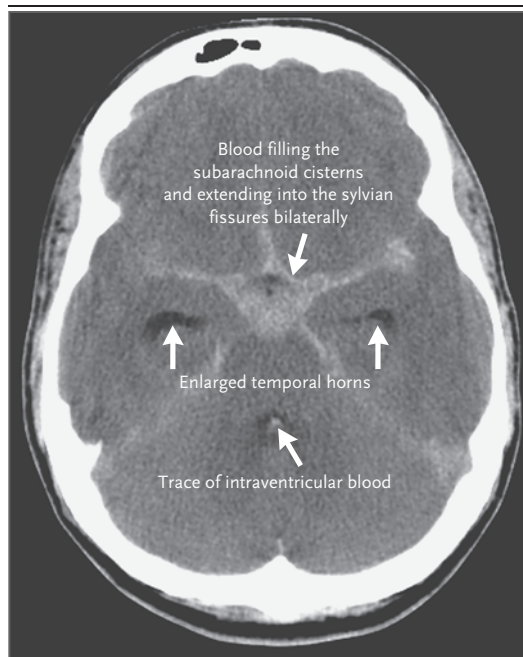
CT Scan of the Head Showing Evidence of Subarachnoid Hemorrhage.
